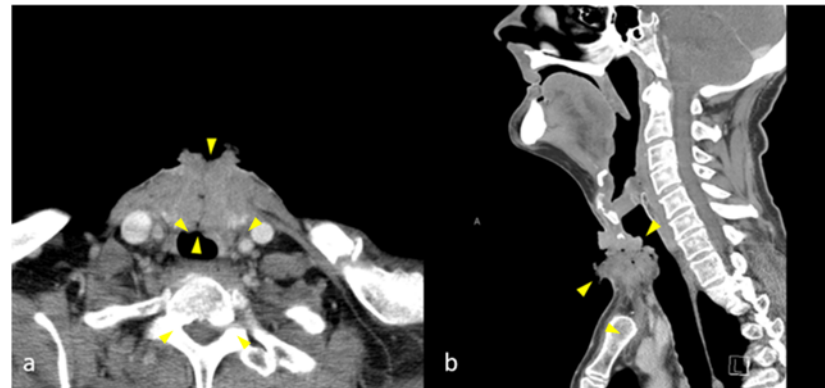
Axial (a) and sagittal (b) CT of the neck with contrast images shows pathology proven squamous cell carcinoma recurrence (yellow arrowheads) which occurred outside of the irradiated area. Long term surveillance of patients with head and neck cancers is advised. This patient had a transoral robotic supraglottic laryngectomy and adjuvant radiation. One year later he developed a fungating mass that obliterated his tracheostomy tract, projecting out through the skin and posteriorly into the trachea. Image courtesy of the University of Massachusetts Medical School, Department of Radiology.
